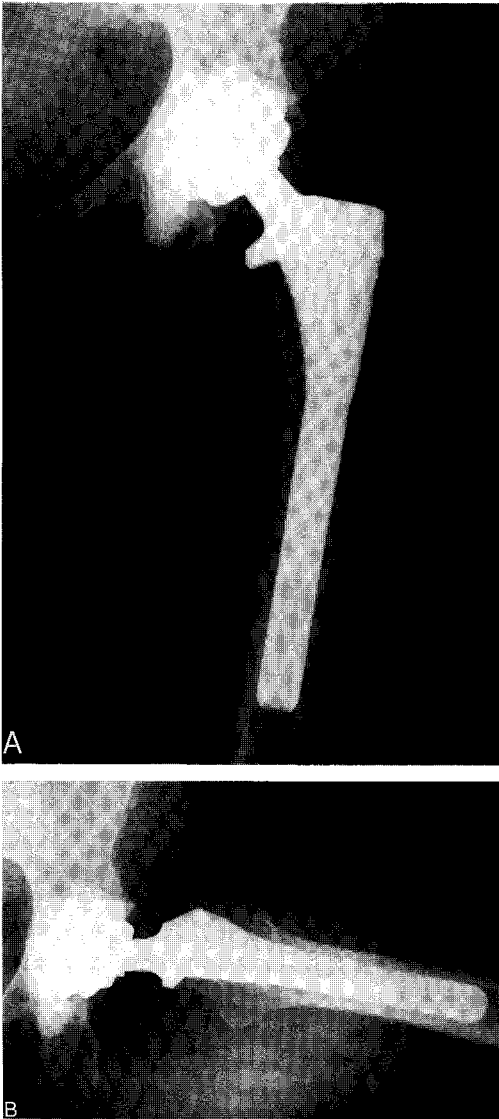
(A) Anteroposterior radiograph of cemented Weber acetabular component and uncemented APR II T femoral component at 2 years postoperative. There is no clear distinction between edge of femoral head and metal articulation surface of acetabular component. (B) Lateral radiograph of metal on metal total hip replacement with cemented acetabular component and uncemented femoral component at 2 years postoperative. There is no clear distinction between the edge of femoral head and metal articulation of the acetabular component.
